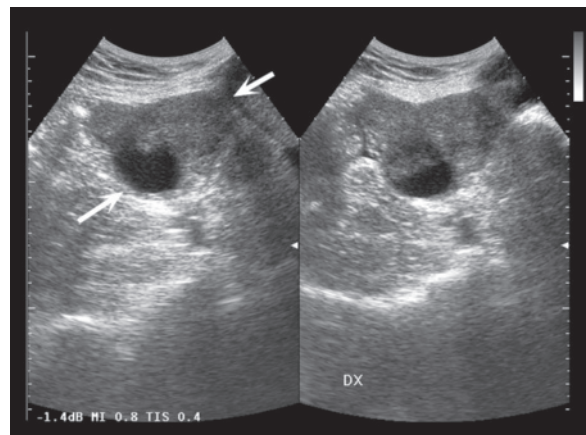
b Ovarian fibroma. Well-defined echogenic mass (*arrows*) with substantially homogeneous echotexture except for the presence of a calcification and an eccentric liquefactive area (a). CT scan (b) confirms the right solid adnexal mass. Left adnexal follicular cyst and slight fluid layer in the rectouterine pouch can also be distinguished
